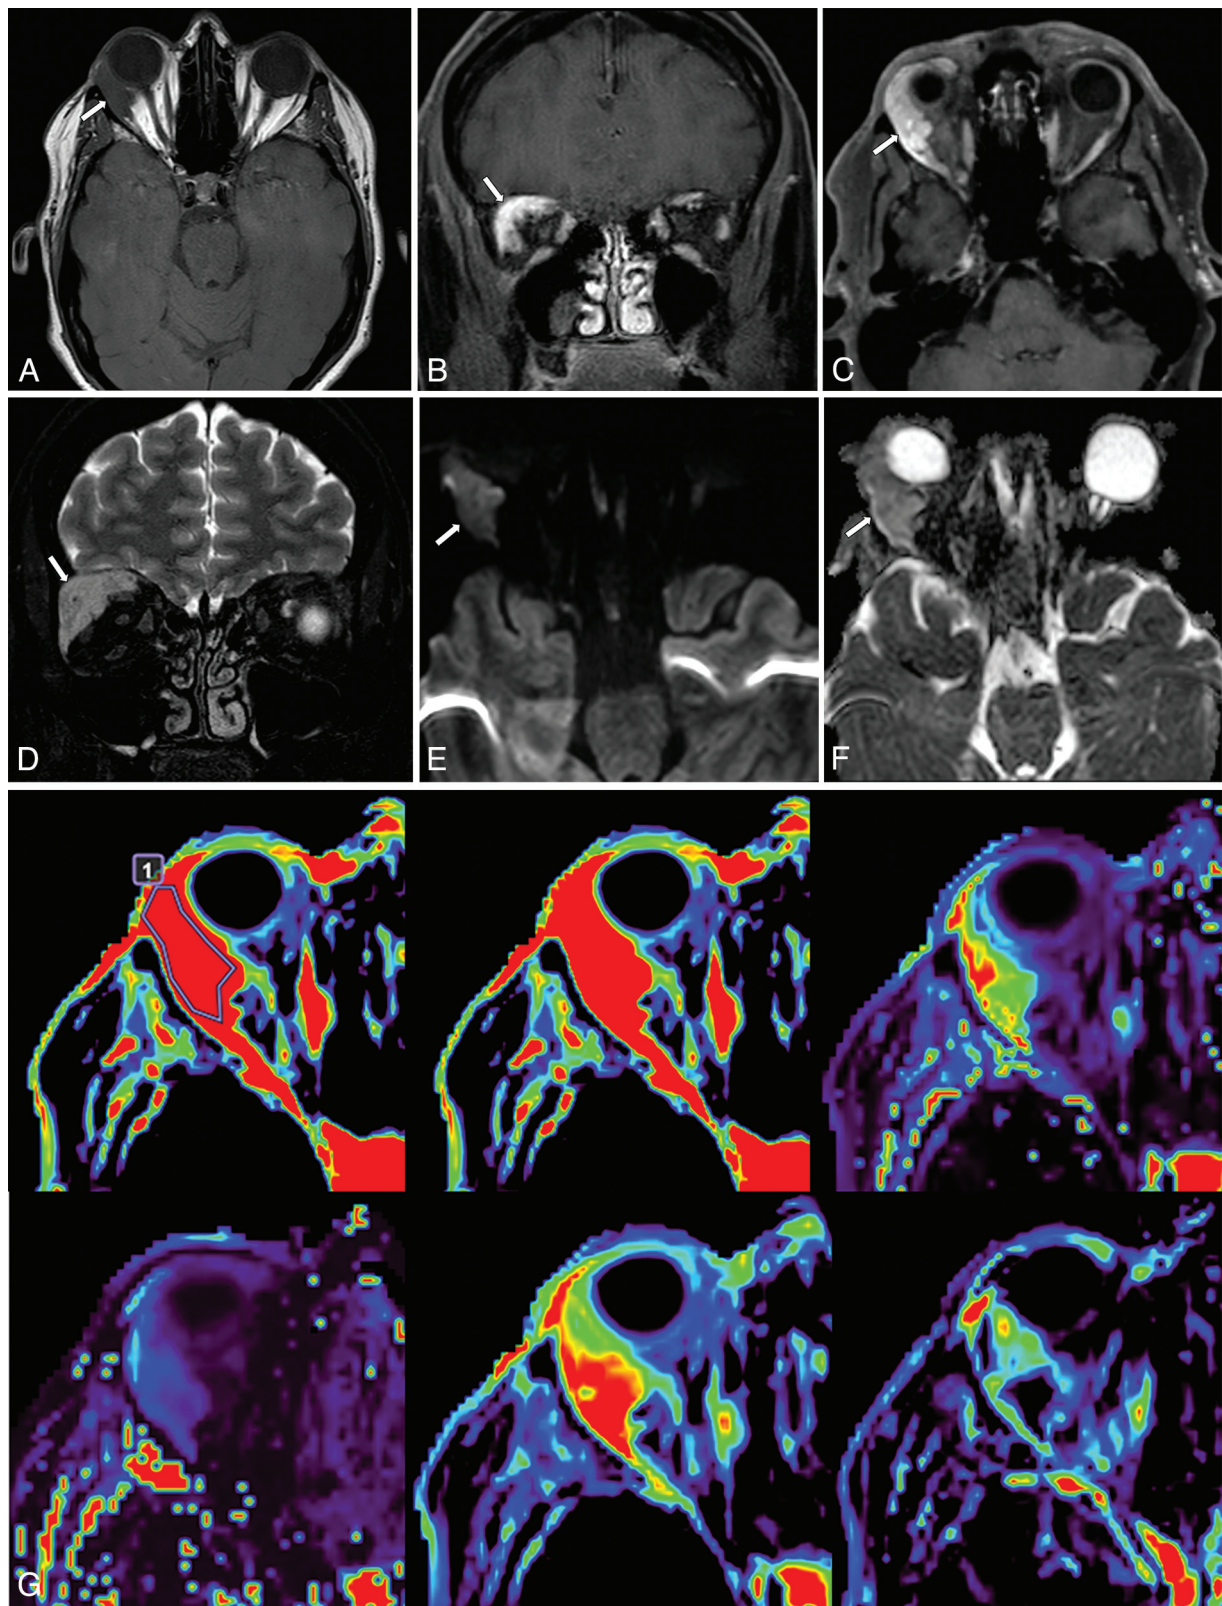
3T MR imaging in a 45-year-old female patient presenting with vertical diplopia. Axial T1WI (A), contrast-enhanced coronal (B) and axial (C) Dixon T1WI, coronal Dixon T2WI (D), axial DWI (E), axial ADC (F), and DCE MR imaging (G) showing a right orbital mass (arrow). DCE colorimetric maps are presented as follows from left to right and from top to bottom: AUC_{DCE} with and without the region of interest drawn, k^{trans} , K^{trans} , V_e and V_p . Postsurgery, the final diagnosis was a carcinoma.
